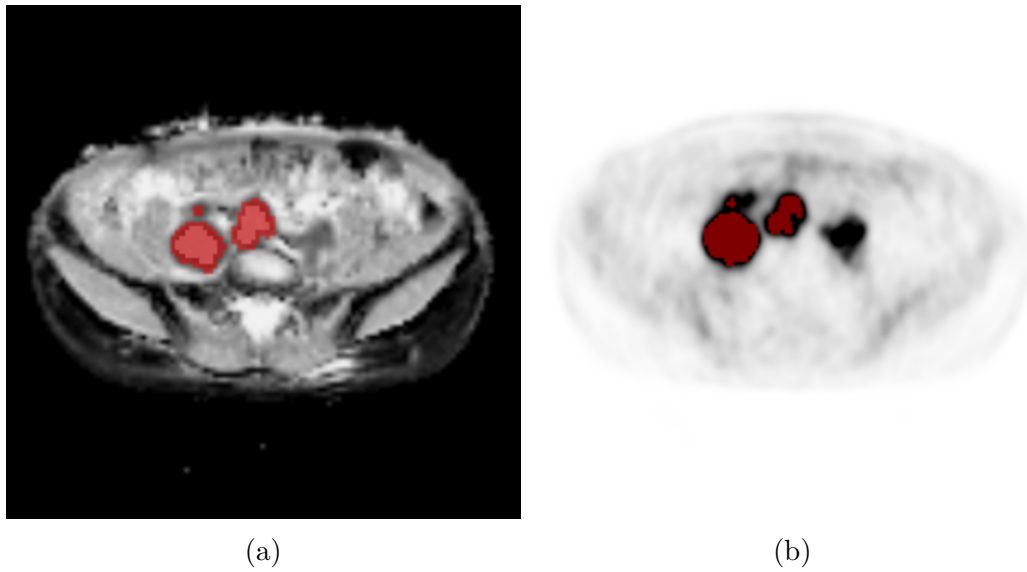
Patient 72, (a) ADC map with manually drawn ROI for ADC analysis, with the whole area of the lesion in red and the inner area of the lesion in light red, (b) PET image from PET/MR with ROI (red), for SUV analysis.
